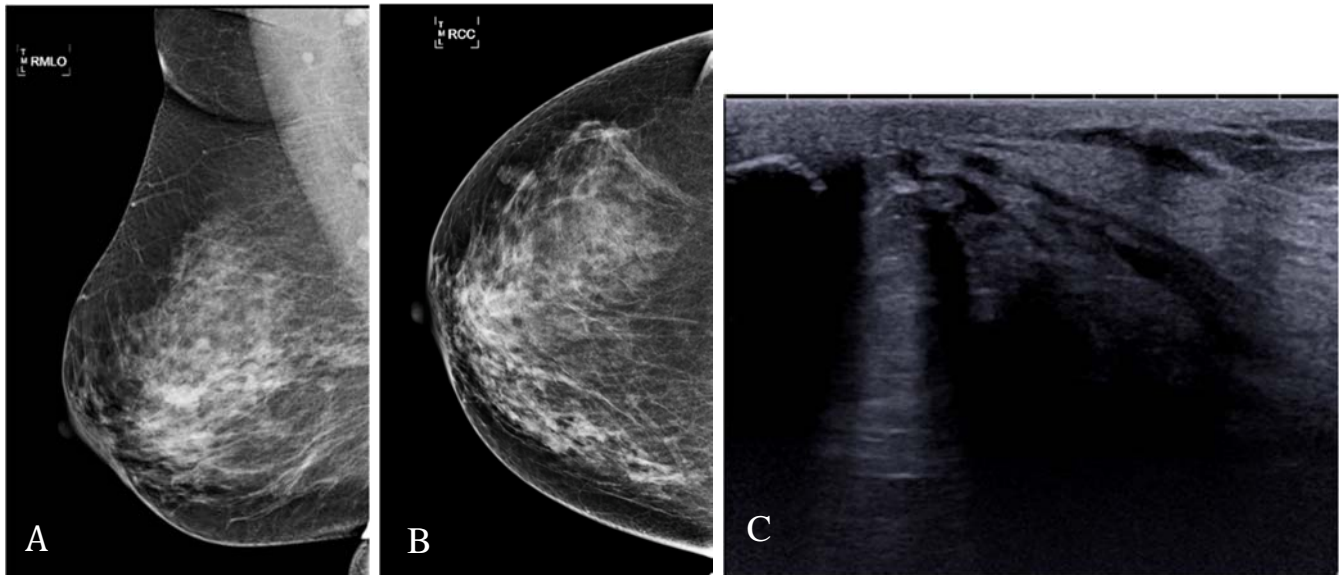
A-C. DCIS on MRI that was occult on mammography, ultrasound and ductography.
